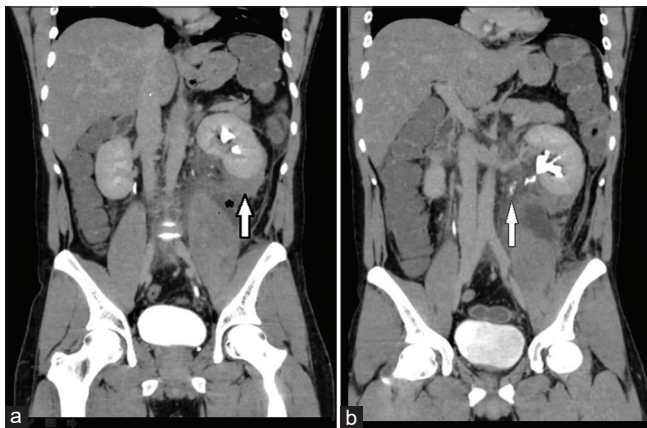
(a) Coronal section of contrast computed tomography abdomen and pelvis showing subcapsular collection in relation to lower pole of the left kidney (arrow) and urinoma over the left iliopsoas muscle (star). (b) Contrast extravasation noted from proximal left ureter (arrow) in delayed phase
